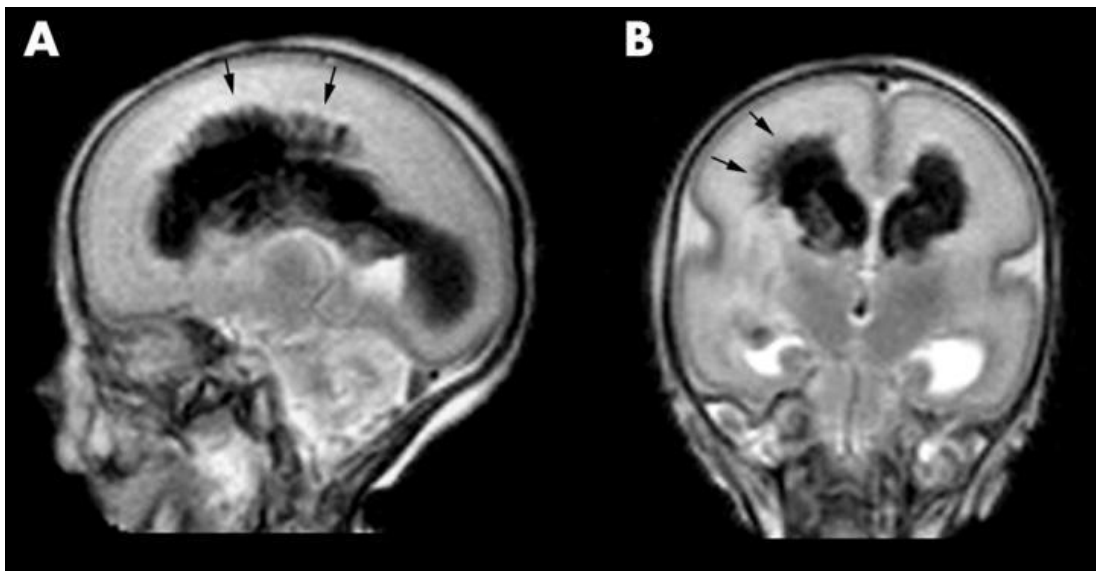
MRI image showing a characteristic injury of the premature brain, germinal matrix - intraventricular hemorrhage on both sides with parenchymal involvement on the right (arrows). A) Sagittal and (B) coronal T2 weighted FSE image of an infant at 27 weeks GA. The images were published by Counsell et al. (19).
